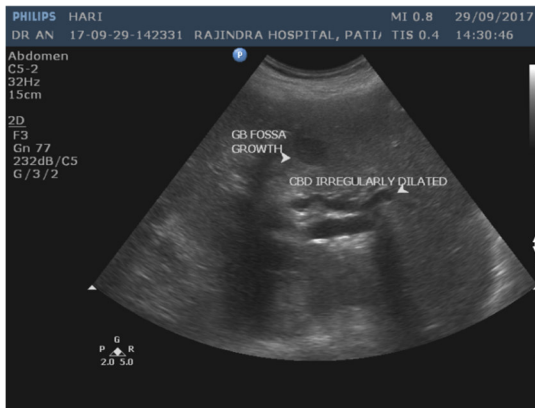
Ultrasonography abdomen showing echogenic lesion in gall bladder fossa region. It is extending to involve common bile duct and causing proximal dilatation of the same.
